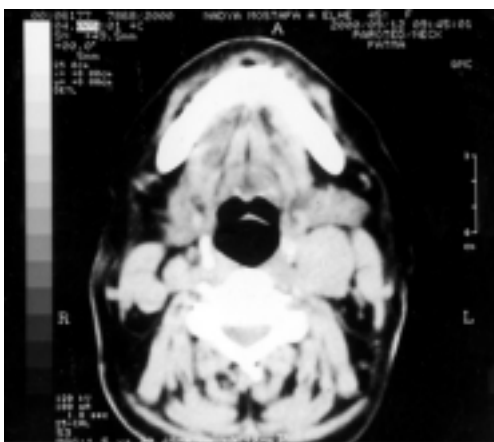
CT of the left CBT.
